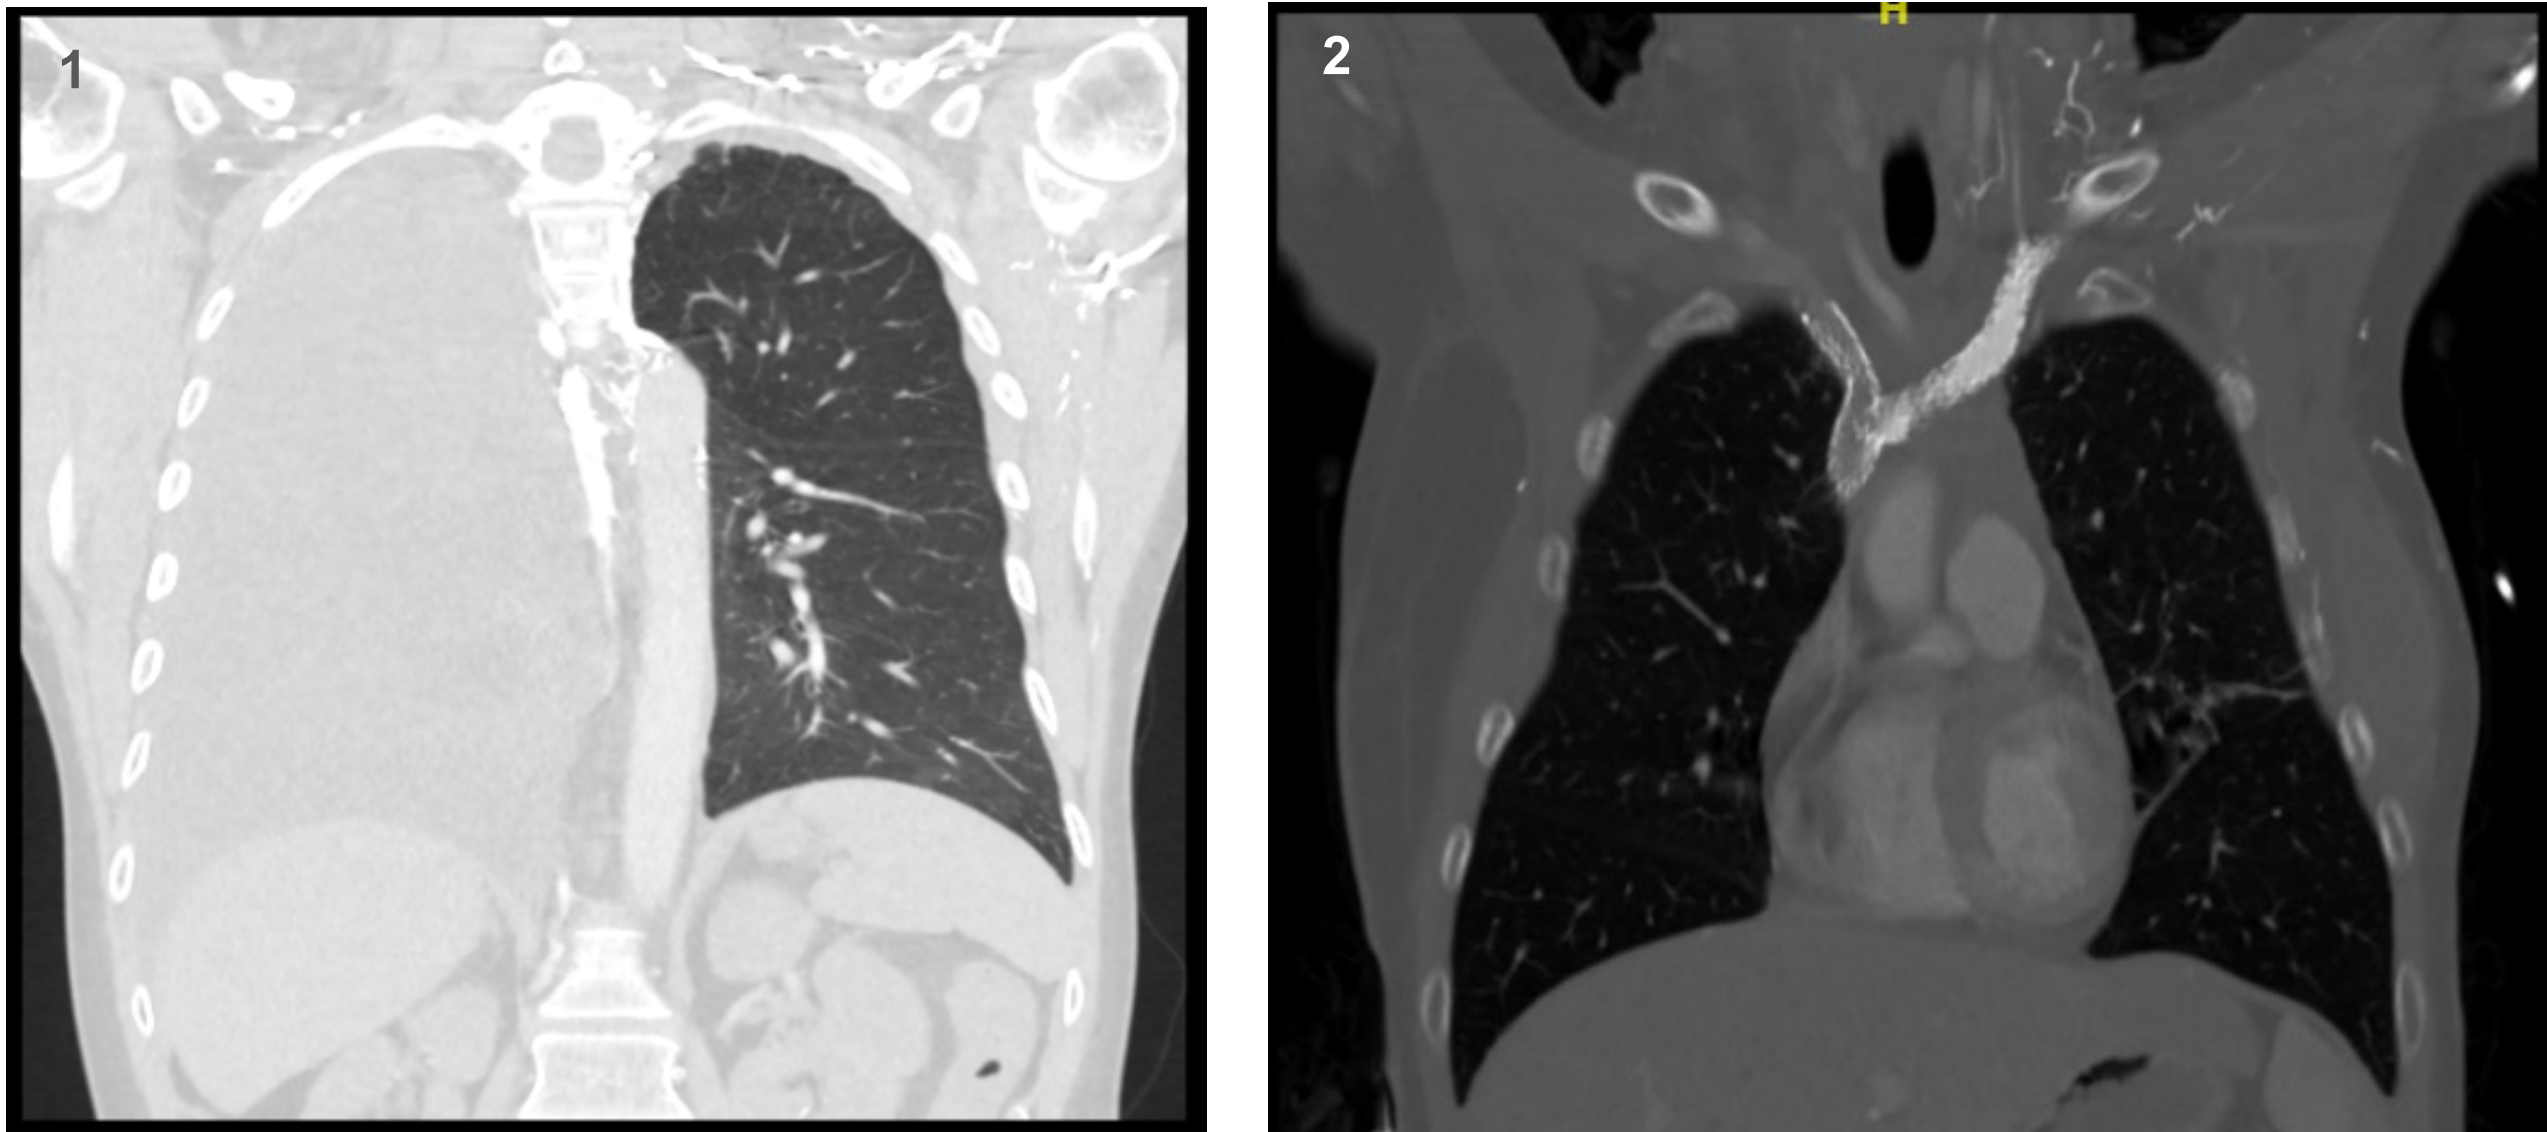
CT scan with right sided chylothorax. Figure 2: CT scan with bilateral brachiocephalic vein stents placed and resolution of chylothorax after pleural catheter.
